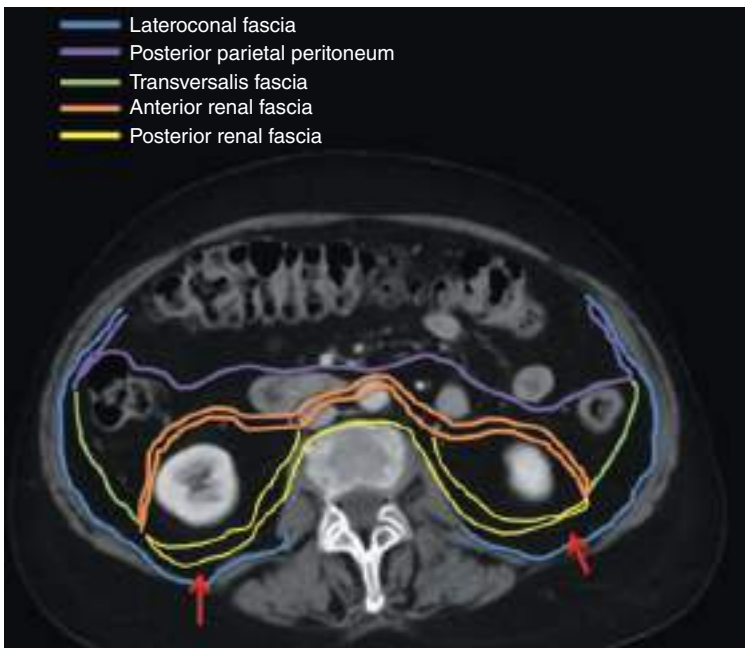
Posterior pararenal space. Axial contrast-enhanced CT image (portal venous phase).
